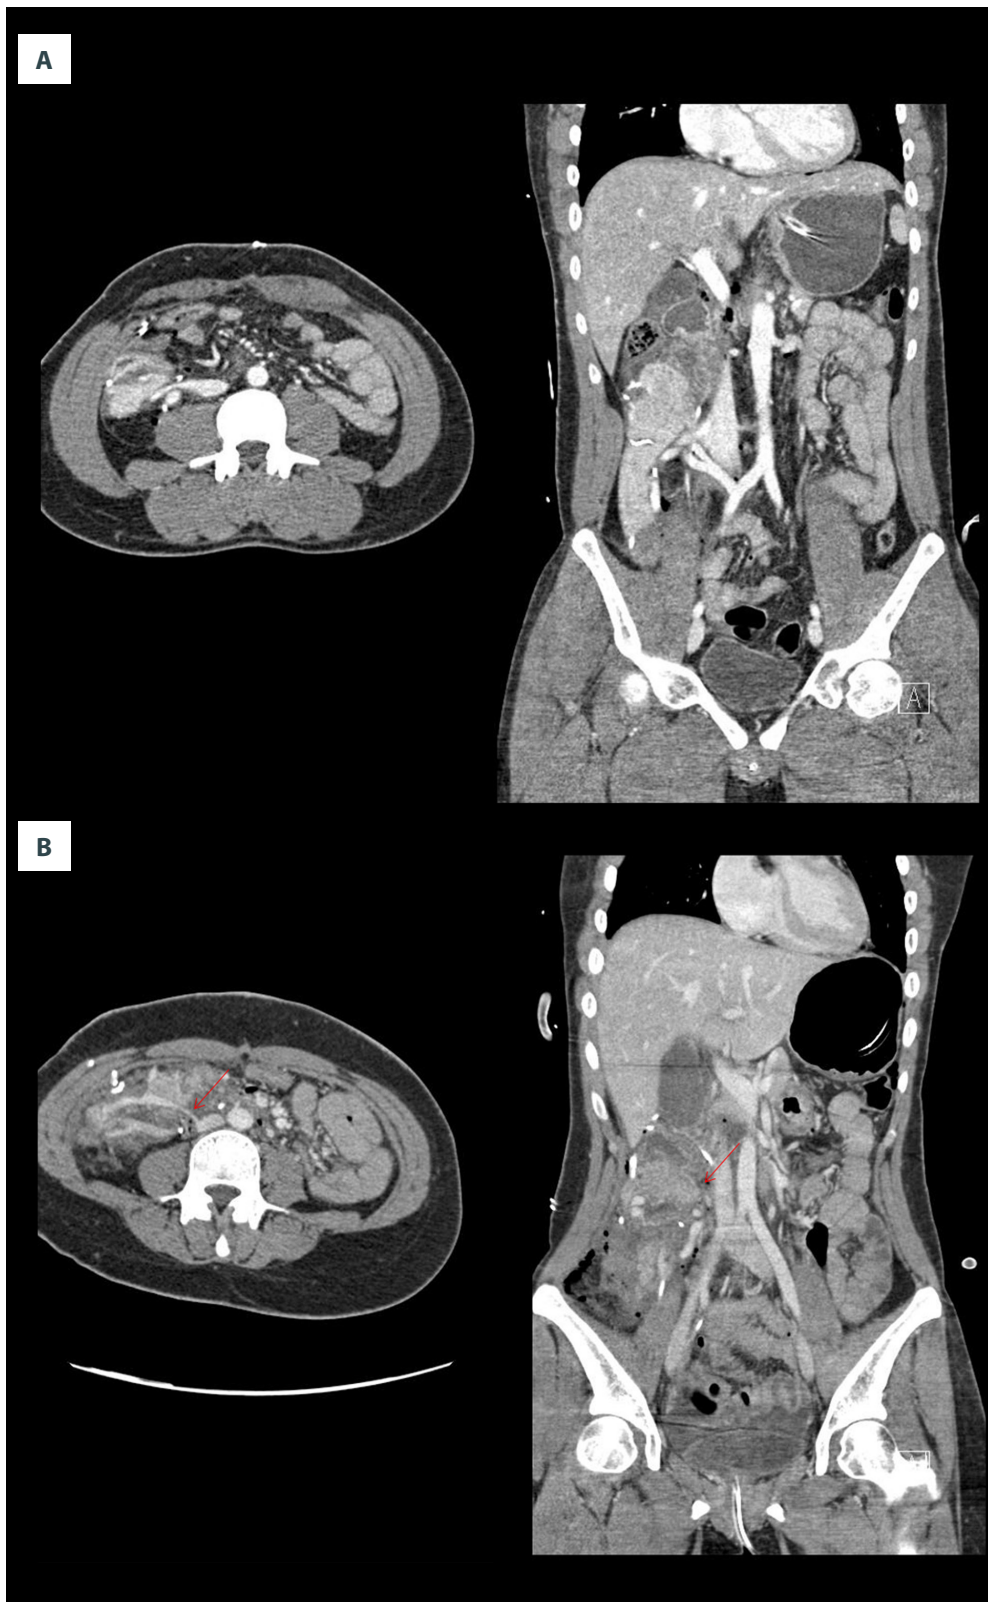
(A) The CT scan in fence angioplasty. Left; Axial view, Right; Coronal view. Wide opening was maintained, as seen in CT scan. (B) The CT scan in direct anastomosis. Left; Axial view, Right; Coronal view. The anastomotic narrowing (red arrow) was seen in CT scan.
